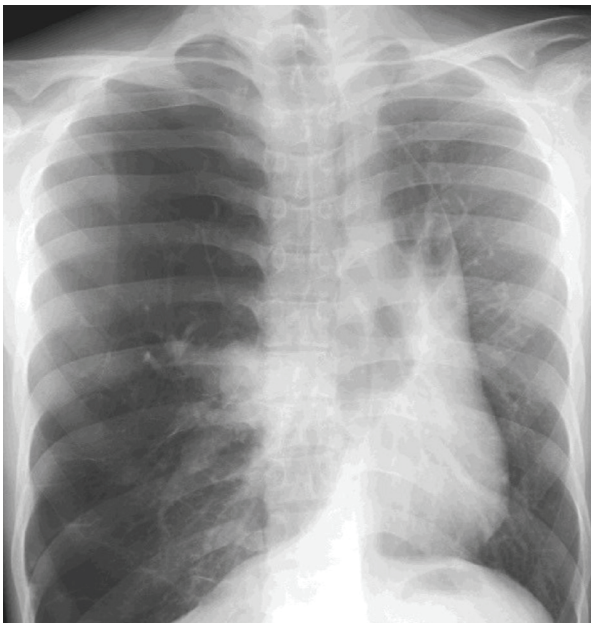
Chest radiography showed an enlarged right lung and reduced lung markings.
